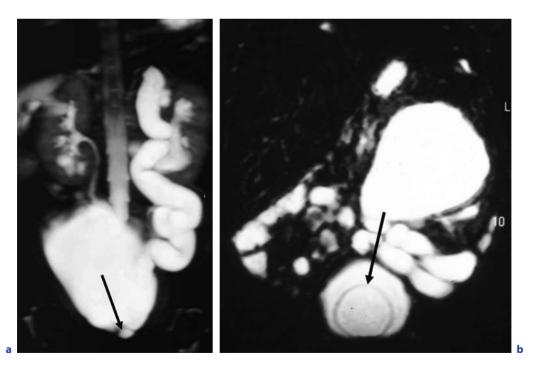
MR imaging in complicated duplex kidney. a Left duplex with obstructed upper pole and ectopic infravesical insertion of the dilated ureter (*arrow*). b Left duplex with obstructed upper pole and ectopic ureterocele (*arrow*)
